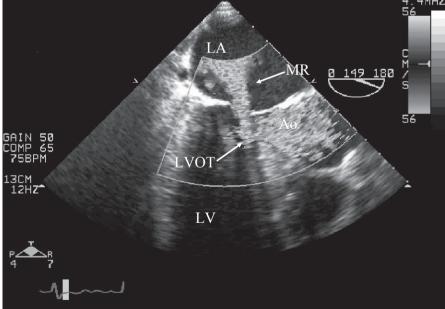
Esophageal multiplane echocardiography.
